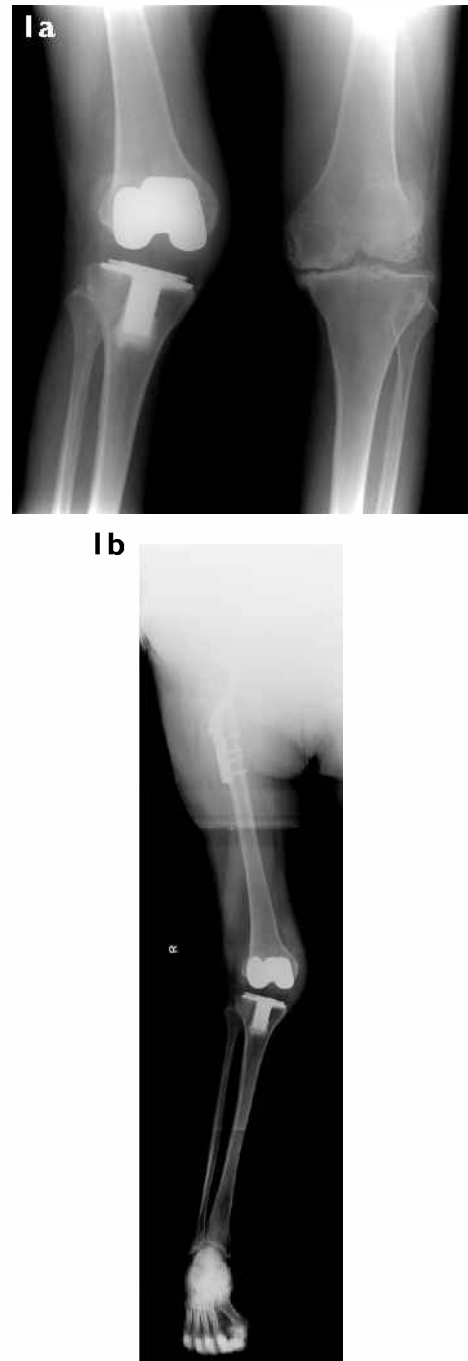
(a) Bilateral anteroposterior knee radiograph shows severe right knee valgus deformity. (b) Right leg long film radiograph shows severe valgus knee deformity.
